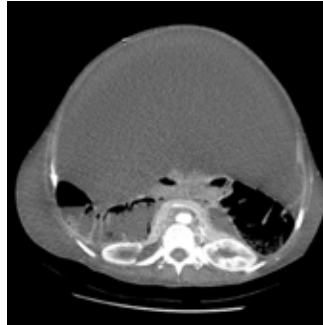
Contrasted Upper Abdominal CT: Diffuse ascites, distant colon loops and air fluid level
